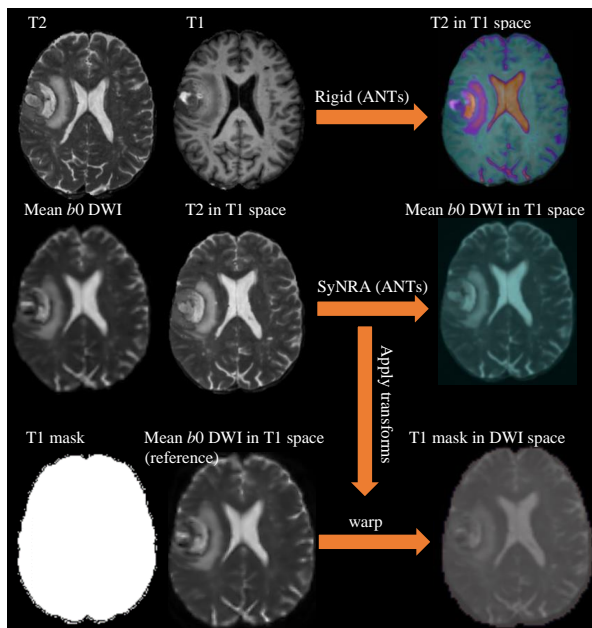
Framework for registration-based EPI distortion correction using T2 and average b_0 DWI volumes. Available transforms from the DWI-T1 registration are later applied for mapping diffusion FODs and other diffusion-derived metric volumes to the T1 image space.
